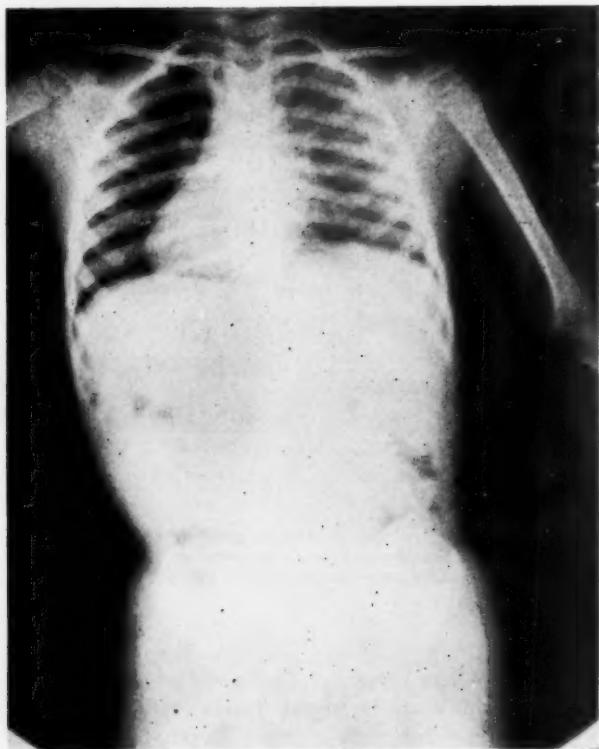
Case 3. Impacted .22-caliber shell, closed end presenting, in the left bronchus of a four year old child. The roentgenogram was made the day of aspiration, so pulmonary complications had not yet developed.
